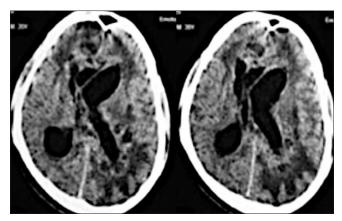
Noncontrast computed tomography brain showing obstructive hydrocephalus along with previous lesions
